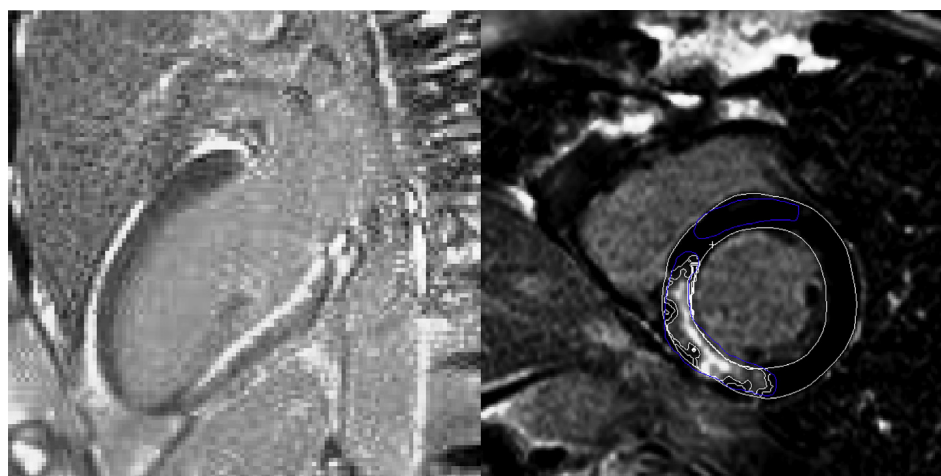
Late gadolinium-enhanced magnetic resonance image of a patient who had a myocardial infarction. Semiautomatic scar detection in segment demarcated to the right.
